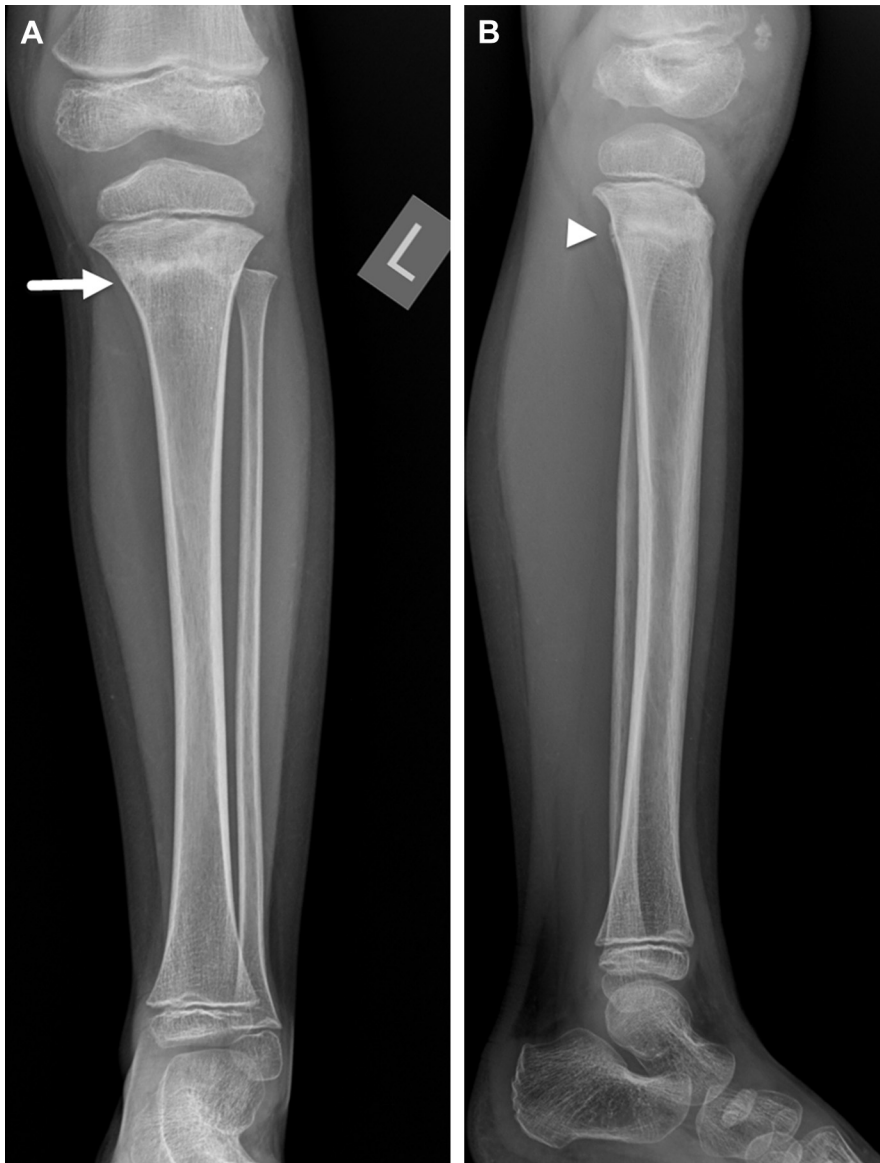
Buckle fracture of the proximal tibia associated to trampoline injury in a 5-year-old boy. (A) Frontal and (B) lateral radiographs obtained 4 weeks after initial injury demonstrate subtle buckling of the proximal tibial cortex with dense transverse sclerotic line (*arrow*) and posterior periosteal reaction (*arrowhead*) in keeping with healing changes. The initial radiographs were interpreted as normal (not shown).
